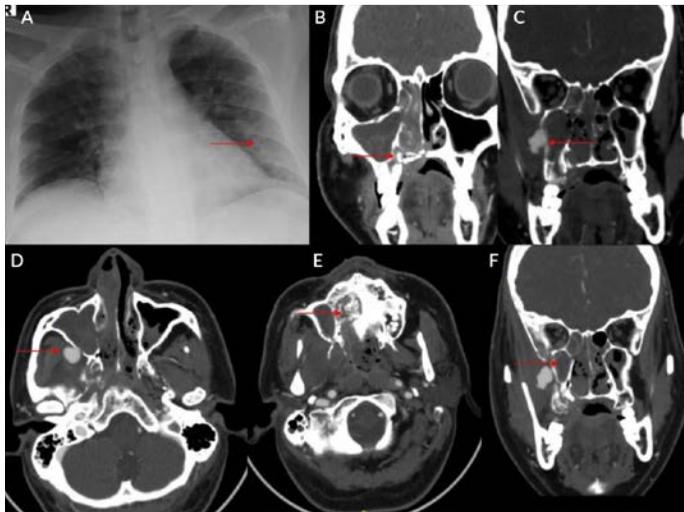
Internal maxillary artery pseudoaneurysm. (A) Chest X-ray shows a small area of consolidation involving the left lower zone. (B) Coronal computed tomography (CT) of the face shows bony destruction involving the anterior part of the hard palate on the right side with hypodense content within the right maxillary and ethmoid air sinuses. (C) and (D) Contrast-enhanced CT face showing a pseudoaneurysm adjacent to the right maxillary sinus arising from the internal maxillary artery. (E) Bony destruction involving the hard palate. (F) Hypodense content noted within the right maxillary and ethmoidal air sinuses.
